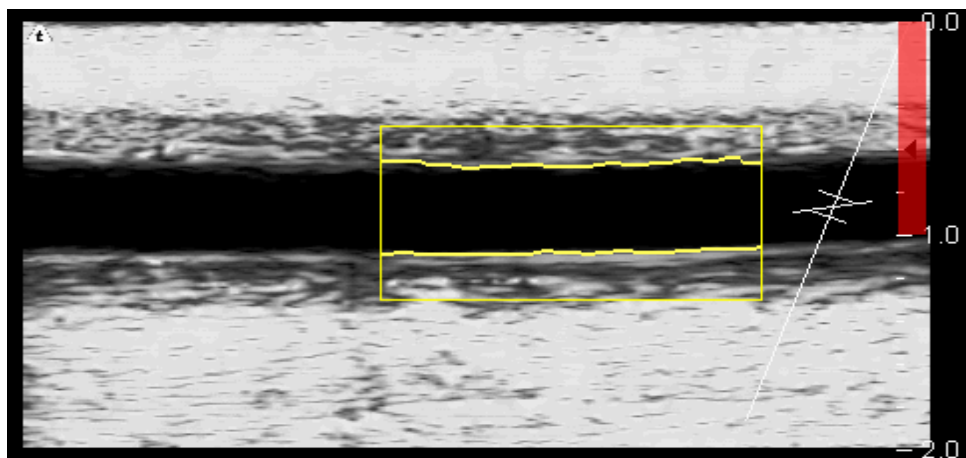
2D B-Mode Ultrasound image recording of the brachial artery in the analysis software with ROI highlighted.
